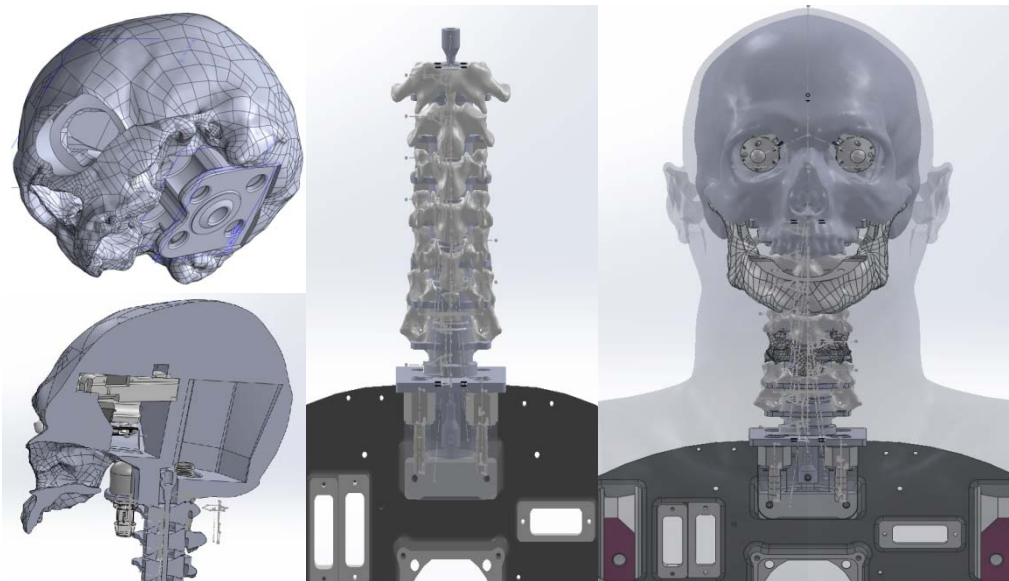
Skull attachment design features for the neck, accommodating anchor sites for the ends of the McKibben muscles; neck system design as mounted to Laerdal structural frame, with CT anatomy spine overlaid; CD model including skull to verify proper scaling and size of neck components.
